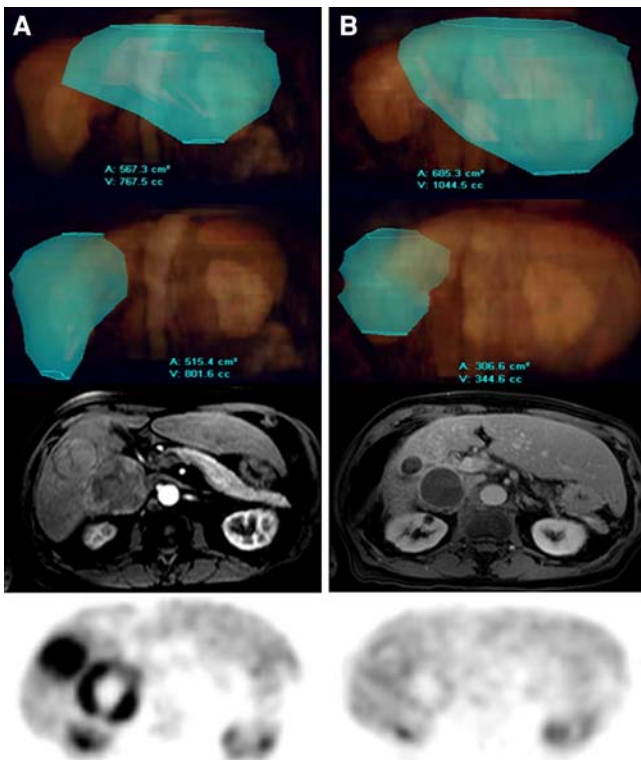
(A) Pre-treatment imaging. Volumetric 3D reconstruction demonstrates a left hepatic lobe and right hepatic lobe volume of 767.5 cc (image i) and 801.6 cc (image ii), respectively. Post-gadolinium T1-weighted MRI demonstrates two large well-circumscribed hepatomas (image iii). Pre-treatment functional axial PET scan demonstrates intense focal uptake of FDG in the HCCs (image iv). (B) Following Y90 treatment to the right hepatic lobe, the left hepatic lobe volume has increased 27% to 1044.5 cc (image i) and the right hepatic lobe volume decreased 43% to 346.6 cc (image ii). T1-weighted gadolinium-enhanced MRI demonstrates markedly reduced size of hepatomas with rim enhancement and complete necrosis (image iii). Note the right hepatic lobe retraction and volume reduction compared to the left hepatic lobe hypertrophy. Functional axial PET scan demonstrates marked reduction in the activity and complete resolution (image iv).
